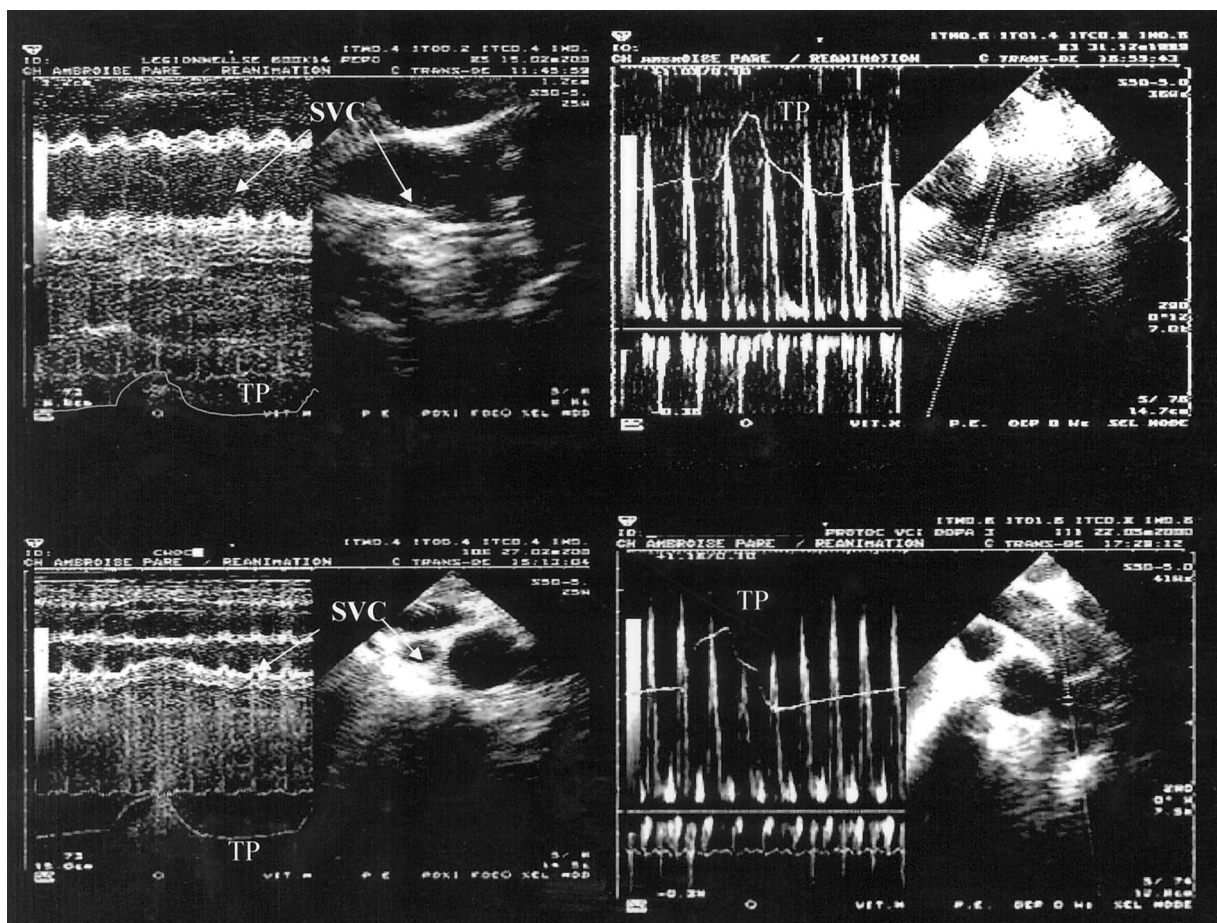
Examples of group 1 (*top*) and group 2 (*bottom*) patients. On the left panel, examination of superior vena caval (SVC) diameter by combined two-dimensional and M-mode echocardiography with simultaneous recording of tracheal pressure (TP) shows minor changes during the respiratory cycle in a group 1 patient, and vena caval partial collapse in a group 2 patient. On the right panel, simultaneous recording of Doppler pulmonary artery flow velocity permits observation of beat-to-beat changes, more marked in the group 2 patient.
